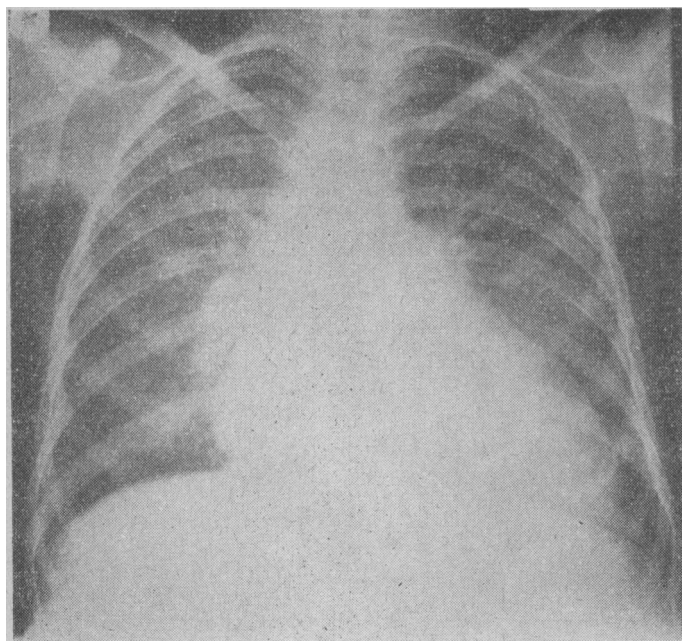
6 ft. postero-anterior chest radiograph on 6 May 1964, showing pulmonary oedema.
